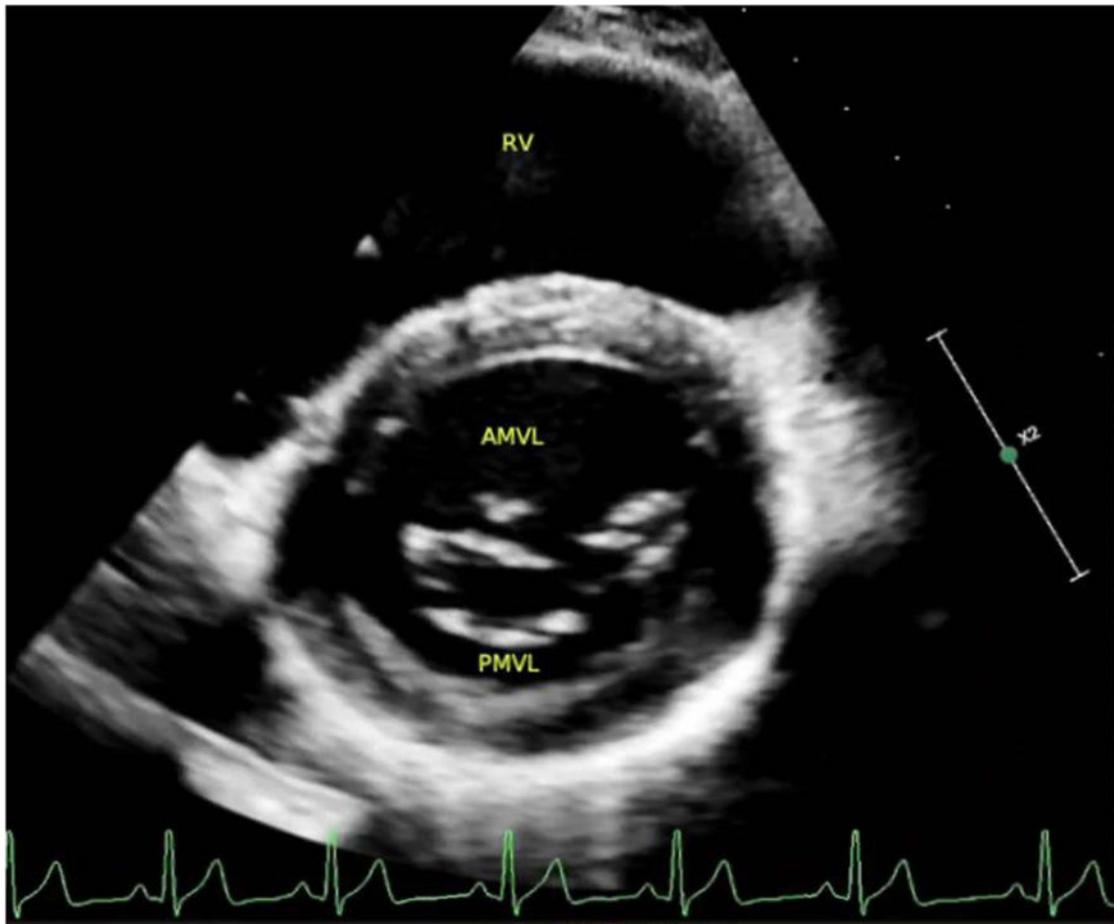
Parasternal short-axis (PSAX) at the level of mitral valve showing anterior and posterior mitral valve leaflets.
